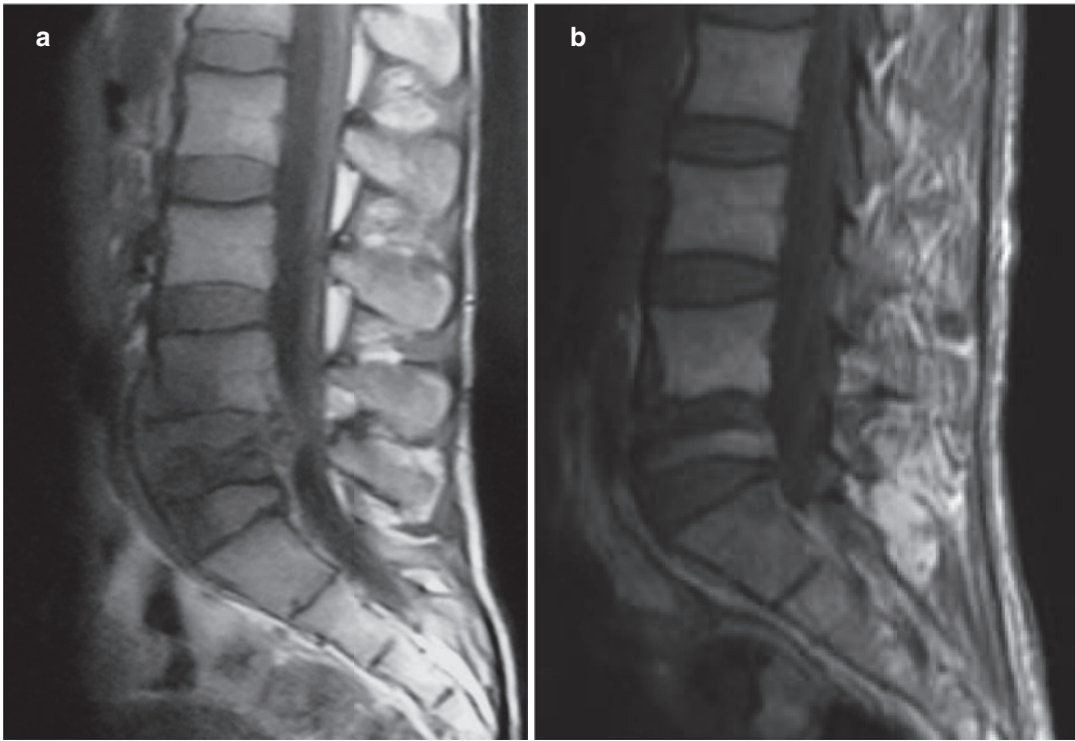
Treated tuberculous spondylodiscitis. Sagittal T1-W MR images obtained (a) pre-treatment and at (b) 2-year follow-up post-treatment shows fatty reconversion of L4 and L5 vertebral bodies indicative of healing. (Fig. 25b is reproduced with permission from: Bouaziz
